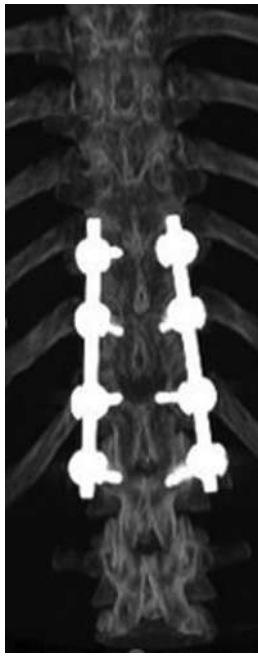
Computed tomography reconstruction.
